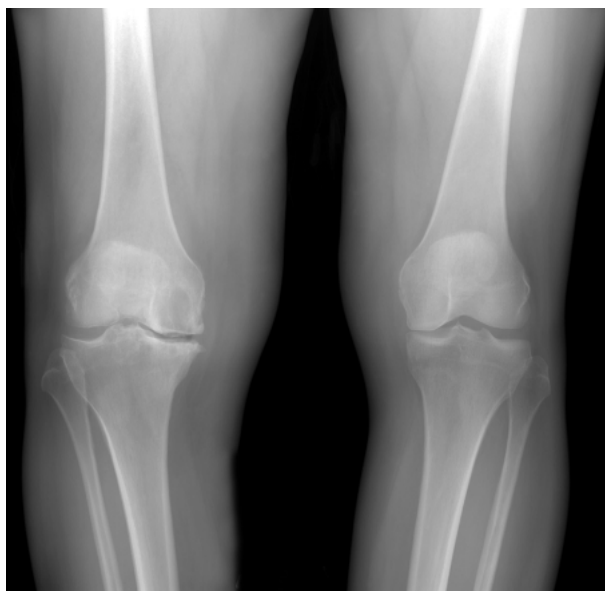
Radiograph showing preoperative end-stage left varus gonarthrosis.
